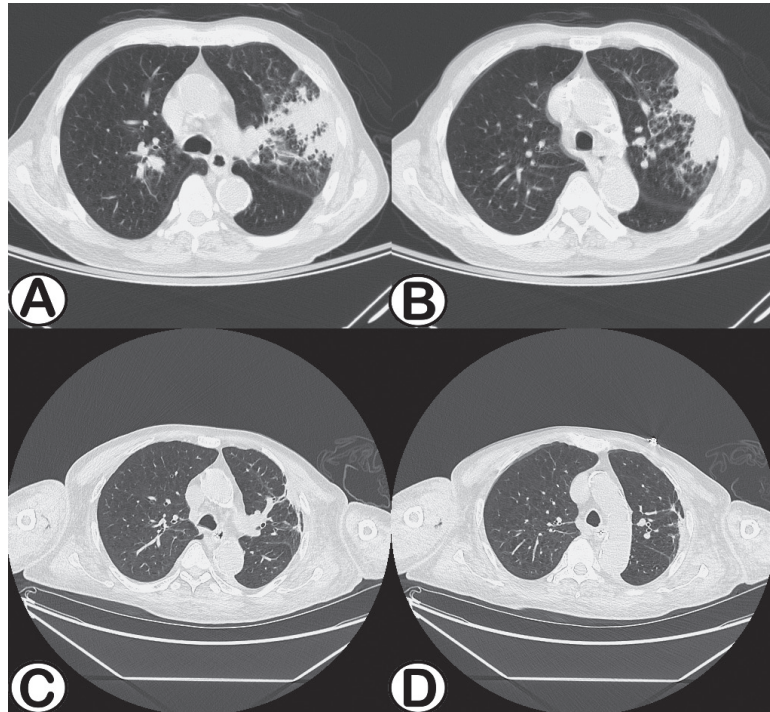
(A)(B) High resolution chest computed tomography on Day 0, showing consolidation of the left upper lobe, with a background of pulmonary emphysema. (C)(D) High resolution chest computed tomography on Day 160 after 1 week of treatment with trimethoprim-sulfamethoxazole plus meropenem, revealing resolution of the consolidation in the left upper lobe.
